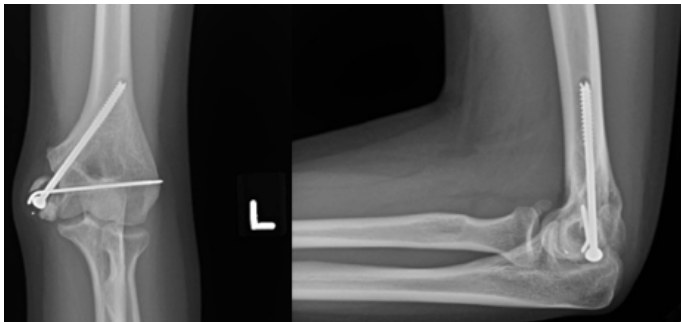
One-year x-rays demonstrate continued nonunion.
